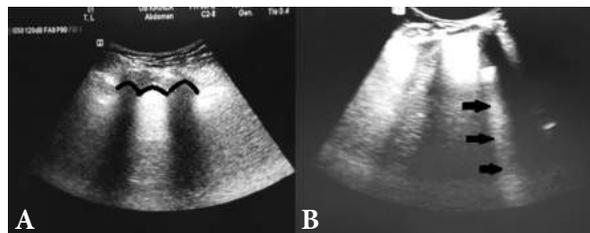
A. Normal lung ultrasound – bat sign visible; B. B line visible on the right, marked with arrows
